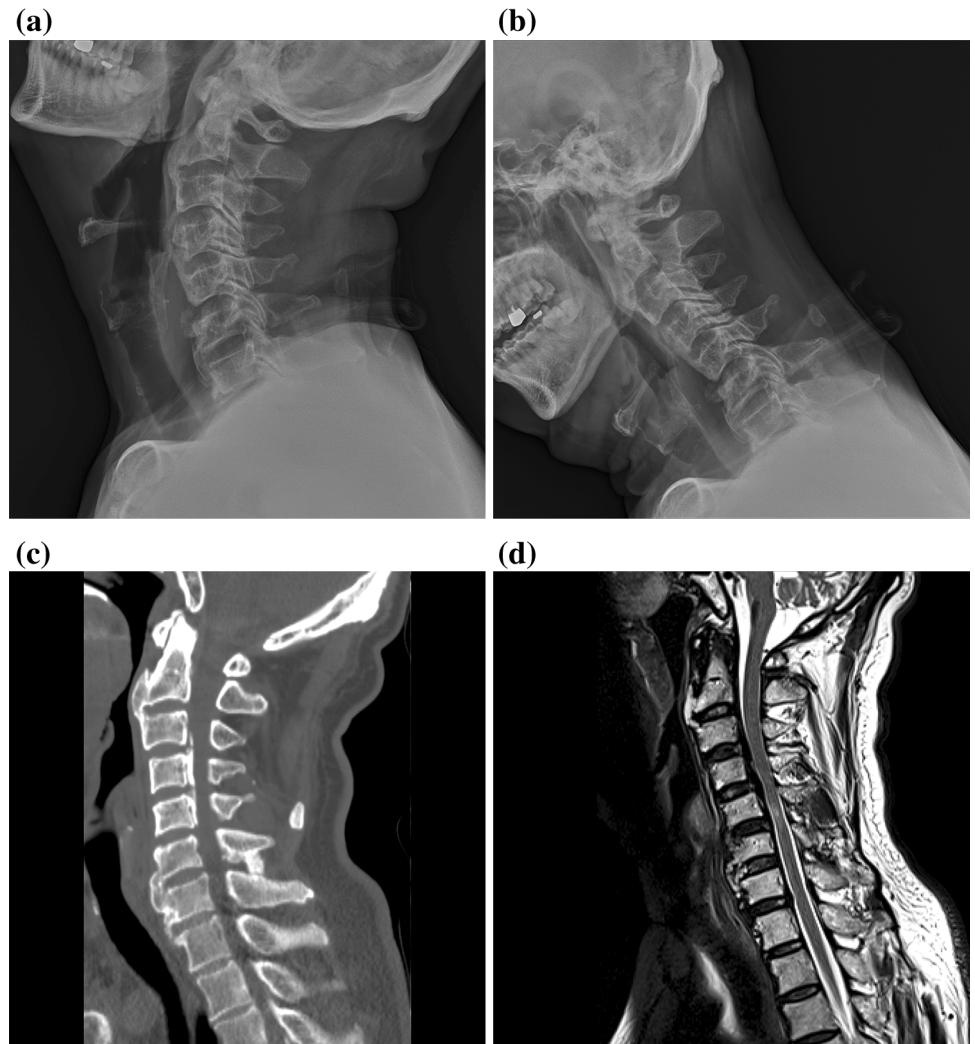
a, b At 9 months after 2nd operation, there was cervical instability in C5–6 on dynamic X-ray. c Spine CT showed more prominent OPLL on C3–5 compared to CT 9 months prior. d MRI showed cord signal change at C5–6
